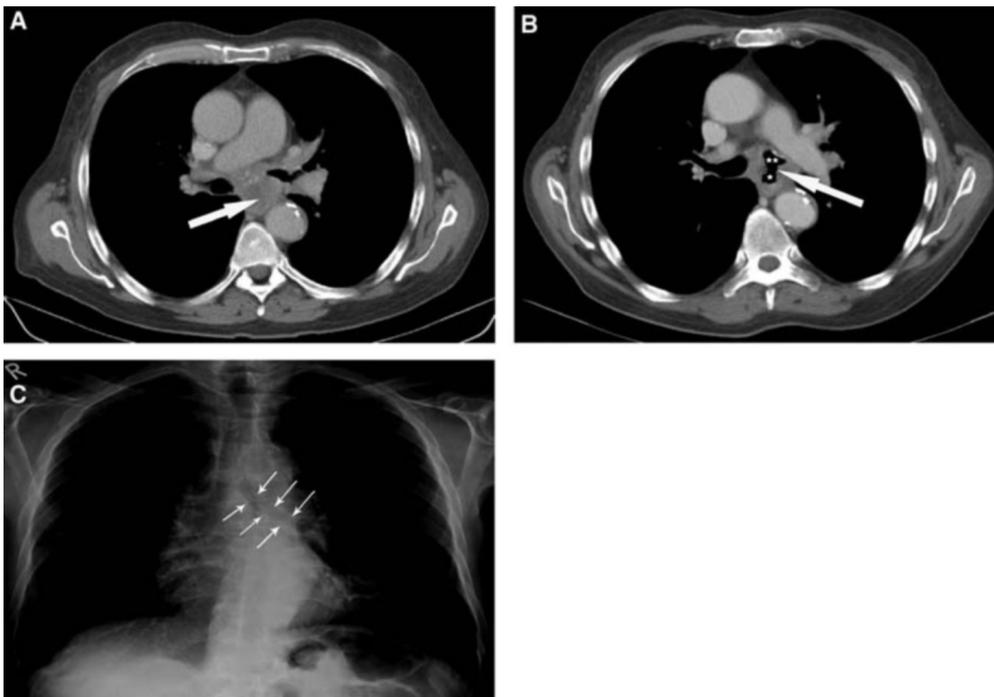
A, Bulky subcarinal and mediastinal lymphadenopathy (white arrow) on staging CT scan before systemic chemotherapy. B, Fistula (white arrow) between esophagus (single asterisks) and left main bronchus (double asterisks). C, Endobronchial stent in the left main bronchus (white arrows).
